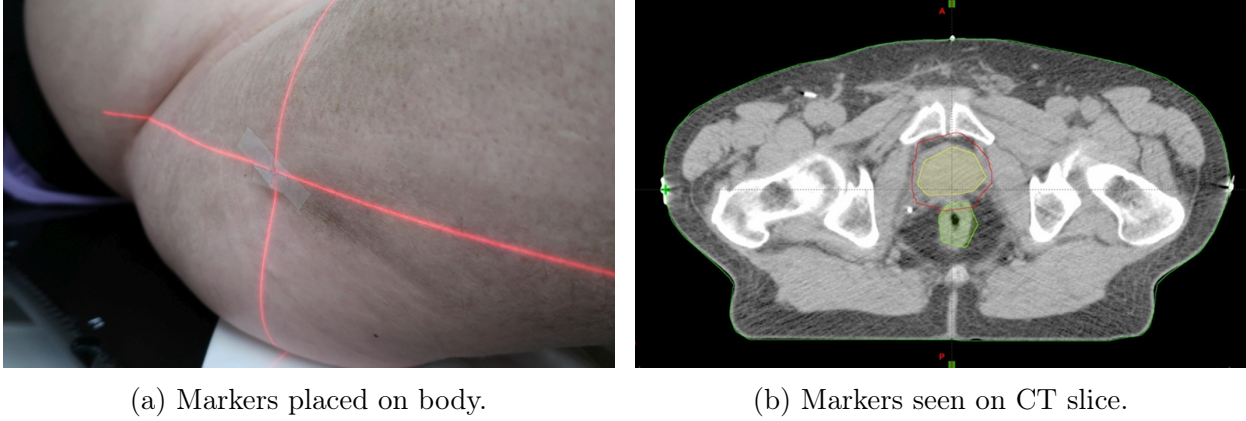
Methodology of transformation of laser crossing point into CT. Radio-opaque markers are placed on patient body prior to CT scan (left figure) in order to represent tattoos. These markers can be seen on CT exam slice (right figure). Photography was taken with patient permission in Maria Skłodowska-Curie Institute — Oncology Center in Warsaw.
